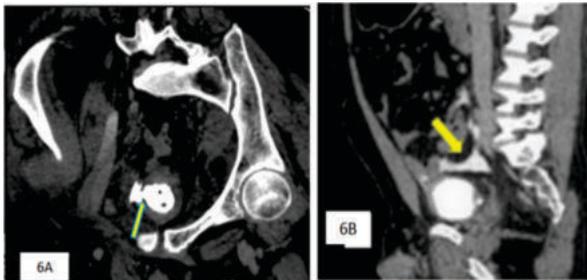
Curved MPR CT image in delayed phase showing rent in the right lateral aspect of urinary bladder wall (shown by yellow arrow) suggestive of bladder rupture.
